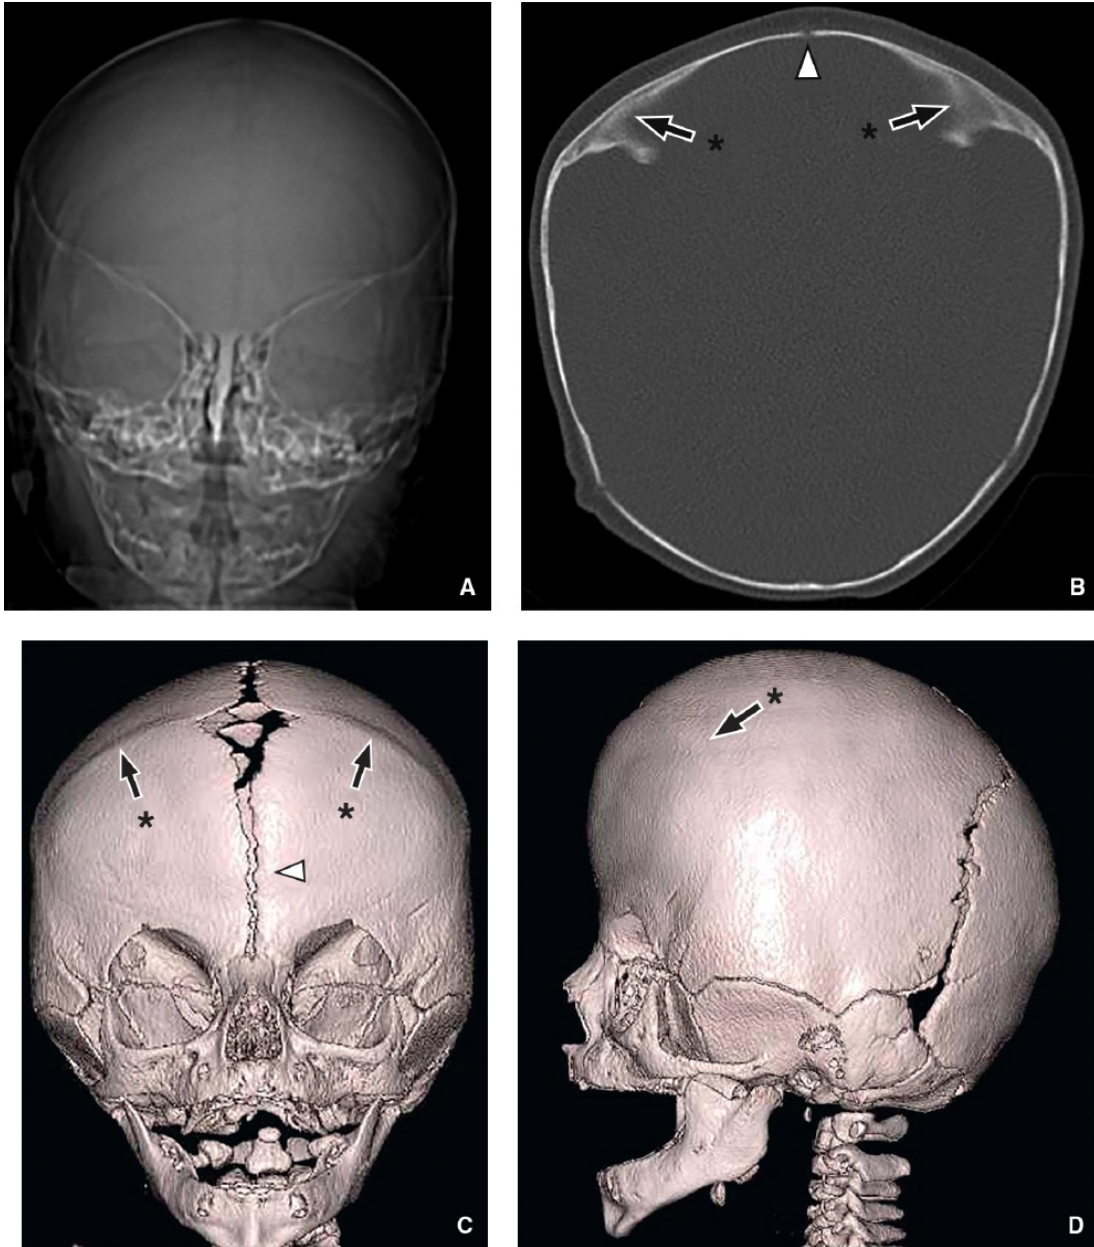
Bicoronal synostosis in a 2-month-old boy with skull deformity. A: Frontal projection CT topogram shows bilateral harlequin deformities of the orbits. B: Axial bone window CT image demonstrates bilateral anterior plagiocephaly and premature fusion of both coronal sutures (*asterisked black arrows* with metopic suture denoted by *white arrowhead*). C and D: Surface rendering CT images confirm premature fusion and ridging of the coronal sutures with upward retraction of the orbits in the frontal view (C) as well as brachycephaly on the lateral view (D).
